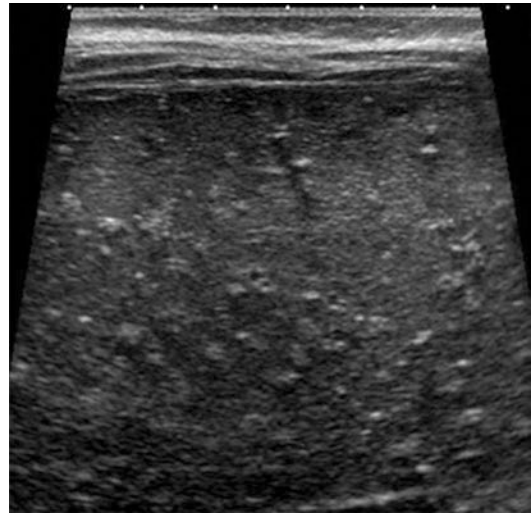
Focal parenchymal lesions in the liver, spleen and kidneys are more apparent on high-frequency ultrasound scanning with a linear probe—such as these hepatic fungal deposits
